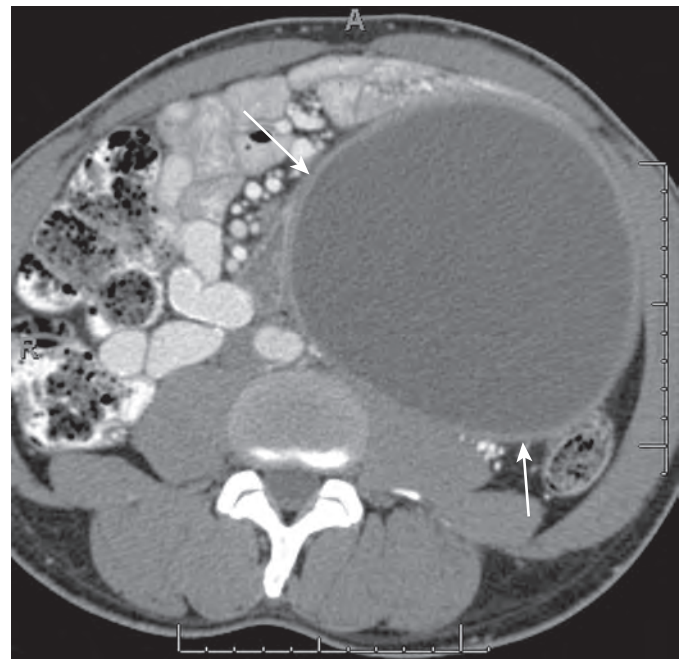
Enteric duplication cyst. Axial CT demonstrating a thick-walled enteric duplication cyst (arrows).
